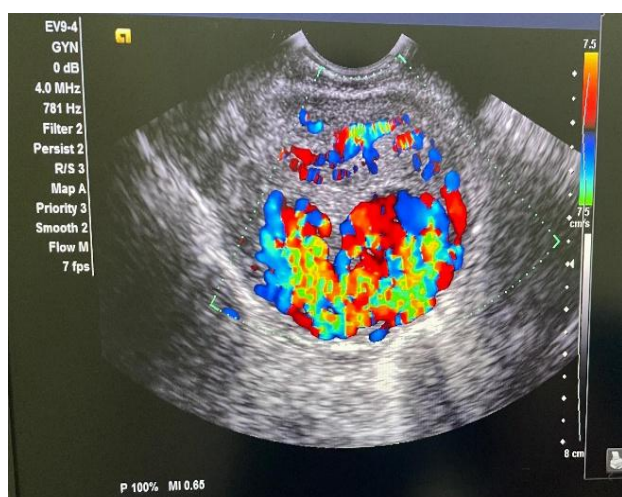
Transvaginal colour Doppler ultrasonography demonstrating a highly vascular retained placental mass infiltrating the left posterolateral myometrium, suggestive of placenta increta.
